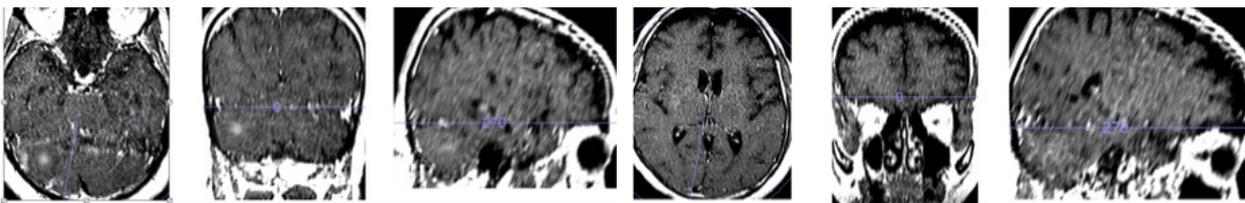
Brain MRI scans
